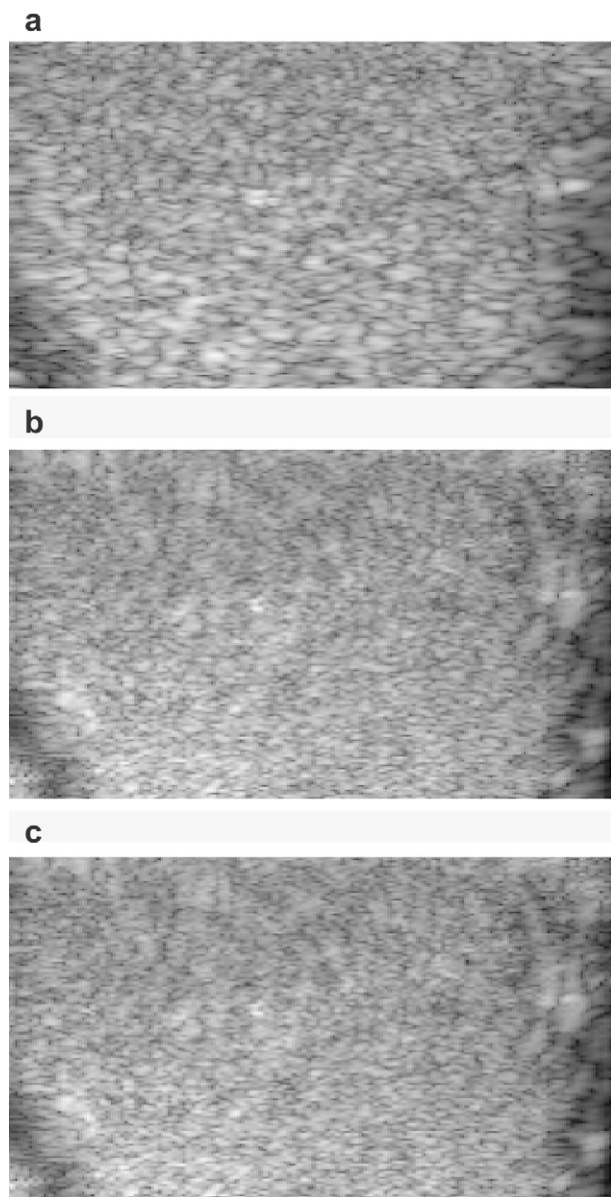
Ultrasound images of an *in vivo* human testicle: (a) original ultrasound image, (b) deconvolution by an optimum speed of 1521.37 m/s and (c) deconvolution by a nominal speed of 1540 m/s. The size of the images is 14.6 mm \times 25.0 mm, when the speed of sound is assumed to be 1540 m/s for comparison purposes. The ultrasound data set is the same as that used in Figure 9. The dynamic range of the logarithmically compressed images is 60 dB.
